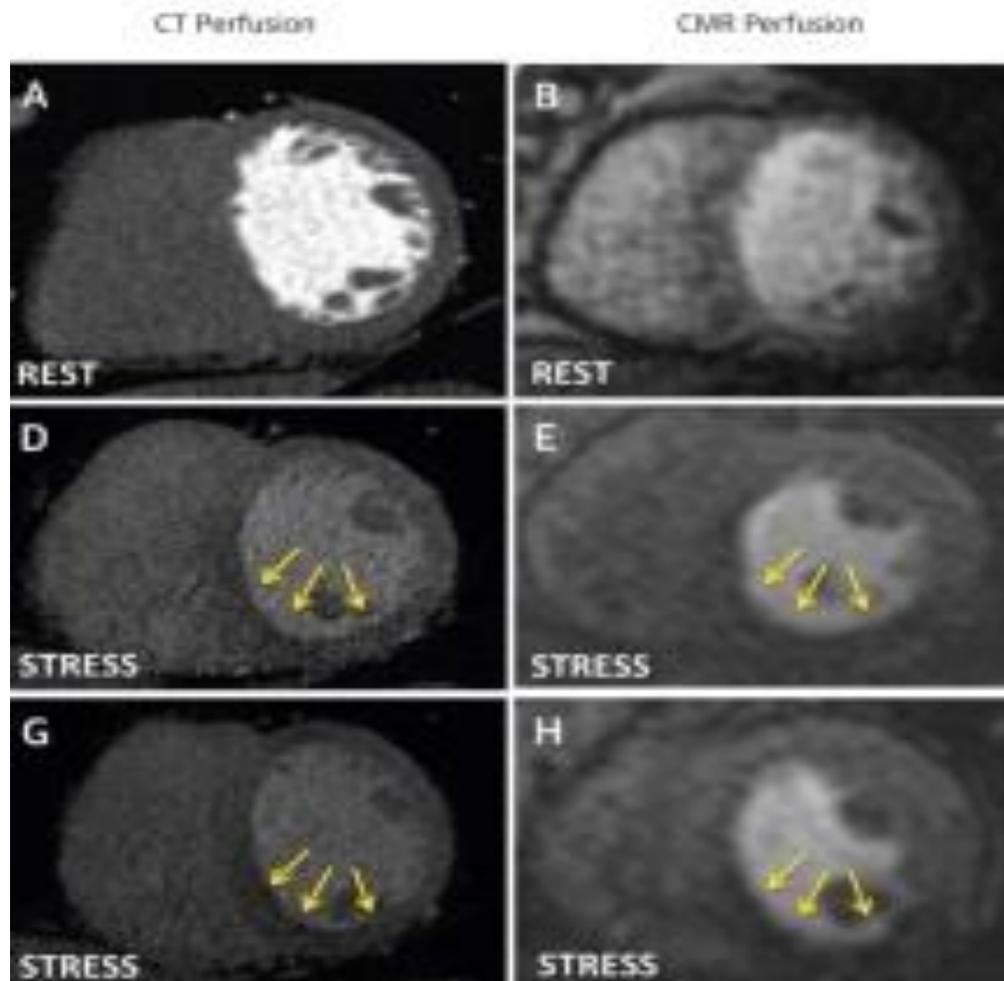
Comparison between CT perfusion and CMR perfusion during rest and stress (Dweck et al., 2016) (Permitted from the author)
